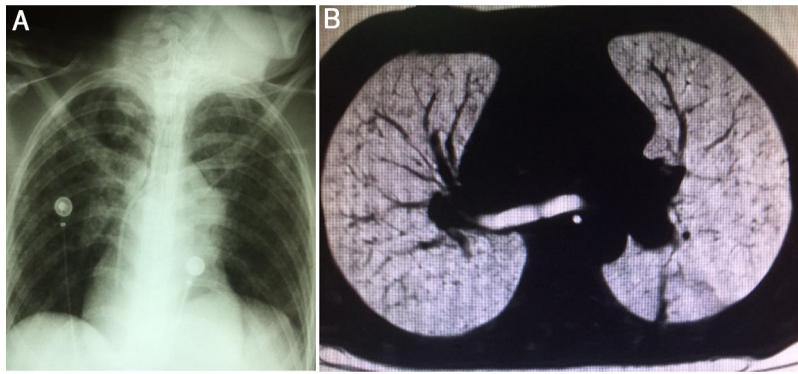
Chest X-ray (1a) and computerized axial tomography (1b) of HIV patient (–) with miliary tuberculosis.
